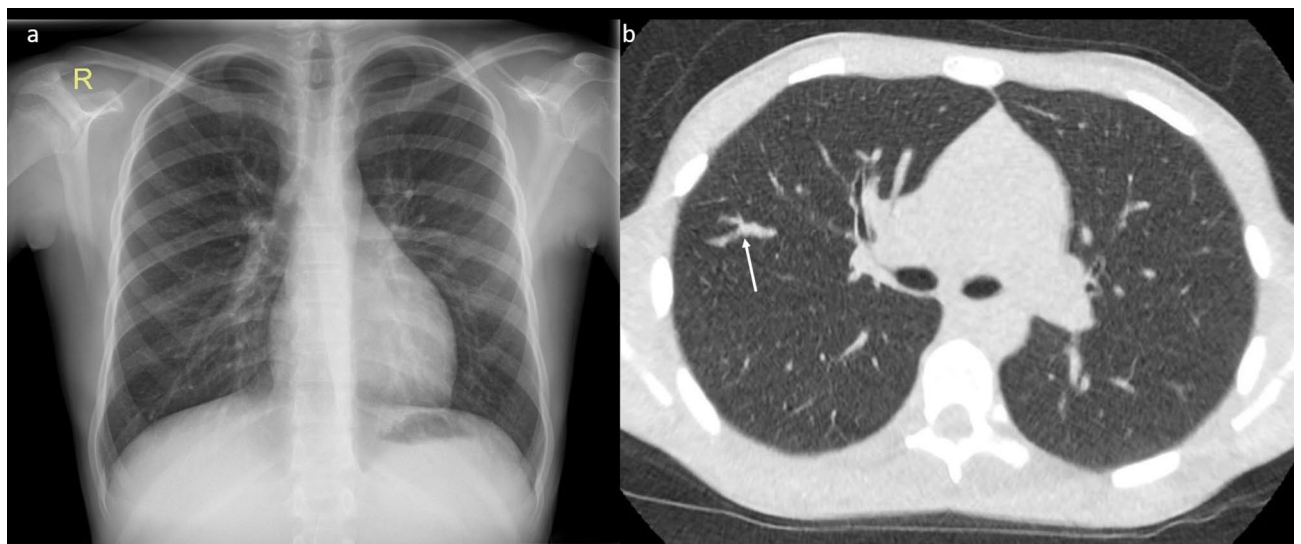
Mucus plugging in chest x-ray versus ULDCT. Image demonstrating a finding of mucus plugging (solid white arrow) in right upper lobe of a 14-year-old male on ULDCT (b). A chest X-ray (a) taken 4 months earlier failed to demonstrate any abnormalities.
